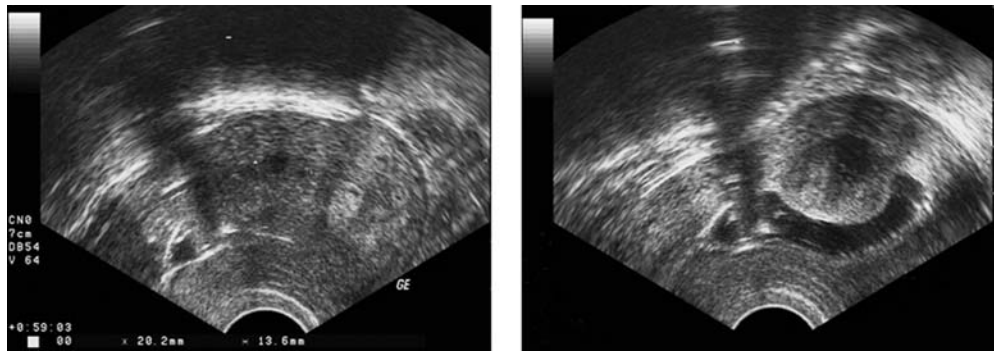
(A and B): Presentation of an intramural fibroid affecting the uterine cavity (FIGO 2), with regular 2D vaginal ultrasound on the left hand side and with hysterosonography on the right hand side.
